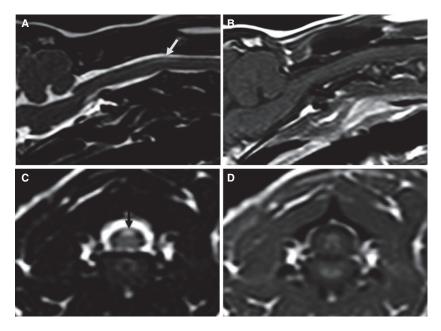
MRI at initial clinical presentation. (A) Mid-sagittal T2-weighted image of the cranial cervical spinal cord discloses a linear hyperintensity in the dorsal funiculus (white arrow). (C) Transverse T2-weighted image at the level of C2-C3 discloses hyperintensity of the dorsal funiculus (black arrow). (B and D) T1-weighted mid-sagittal (B) and transverse (D) images at the corresponding levels as (A) and (C), respectively.
